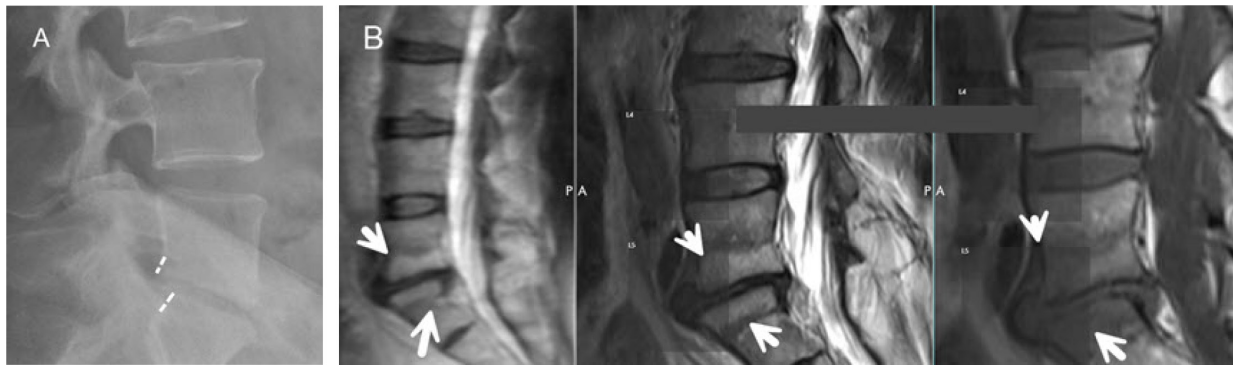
(A) Lateral x-ray retrolisthesis with disc narrowing seen at L5–S1 in 42-year-old nurse. (B) Sagittal T2-weighted, short T1 inversion recovery, and T1 weighted magnetic resonance images show Modic 1 changes of L5 and S1 with moderate-severe disc degeneration. This spondylolisthesis without pars defect responded well to basivertebral nerve ablation. The preoperative visual analog scale score of 8 cm improved to 1 cm and Oswestry Disability Index improved from 52 to 10 points.
